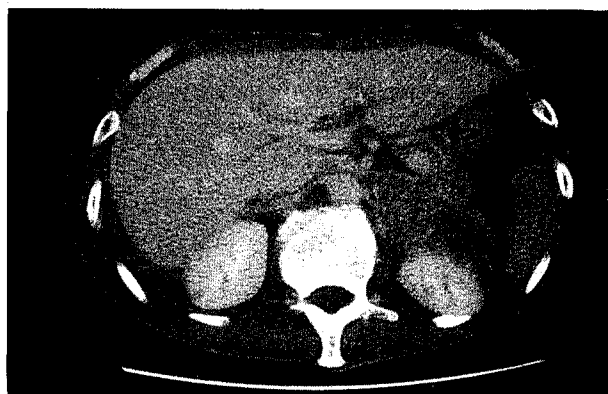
Computed tomographic scan showing the left adrenal metastasis of lung cancer
